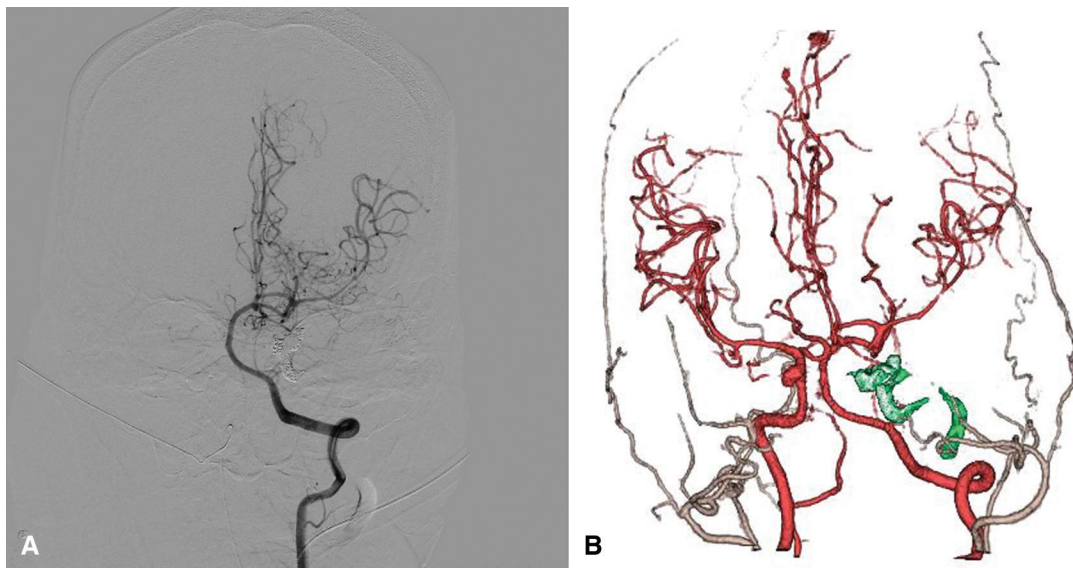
Right vertebral angiogram in the anteroposterior view (A) after endovascular treatment showing cross flow via the posterior communicating artery. CT angiogram in the anteroposterior view (B) after endovascular treatment showing complete occlusion of the left ICA and blood flow to the peripheral middle cerebral artery. CT: computed tomography; ICA: internal carotid artery
